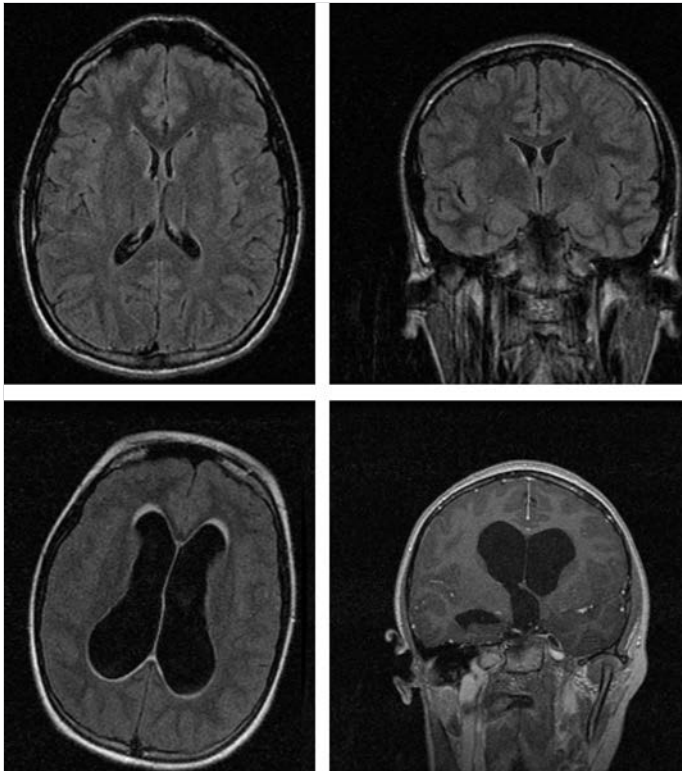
Top panel: Axial and coronal views of T1-weighted MRI sequences demonstrating lateral and third ventricles of typical caliber for a healthy adult. The bottom panel images demonstrate significant ventriculomegaly of the lateral and third ventricles. The anterior and posterior interhemispheric approaches may be used to access the ventricular system in the absence of ventriculomegaly.
